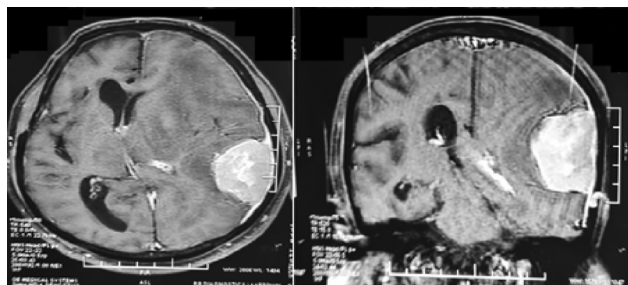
Magnetic resonance imaging (MRI) brain contrast in November 2020 left temporal convexity meningioma with midline shift to right.
